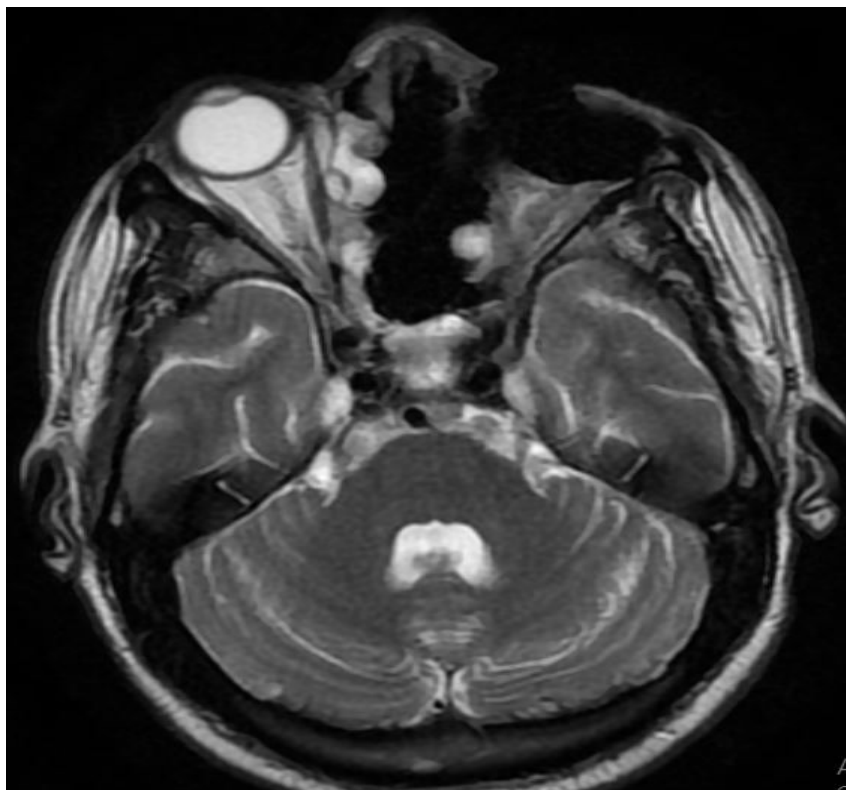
Status post Exenteration left eye- MRI image - Axial T2WI showing defect in the left orbit
